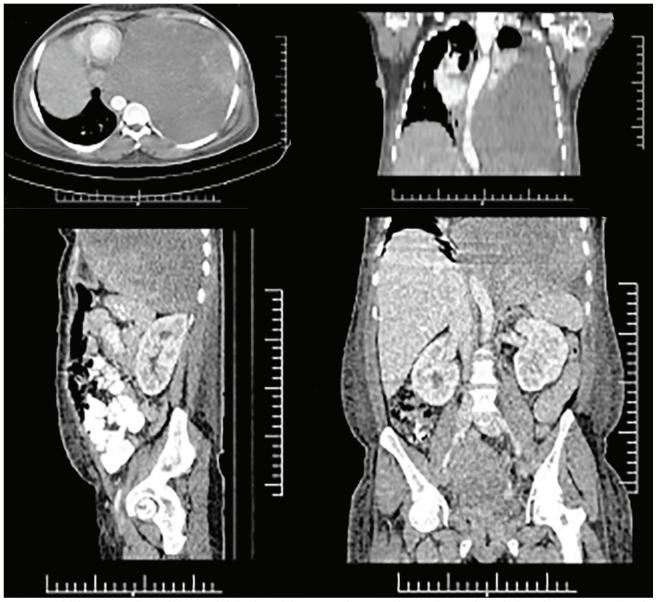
Initial contrast-enhanced chest and abdominopelvic computed tomography scan image showed a huge homogeneous, sharply defined mass in the left pleural cavity, compressing the heart and the descending thoracic aorta, with pressing the left hemi-diaphragm downward against the spleen and stomach.
